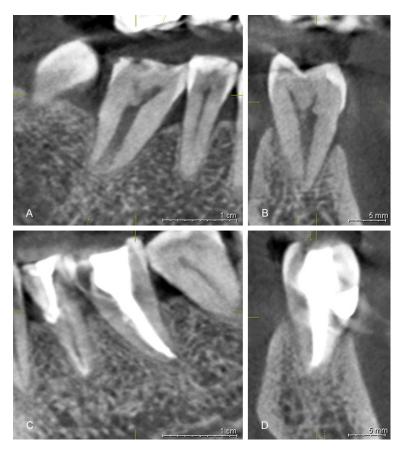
The cone-beam computed tomography image of the right mandibular first molar in the transverse (A) and sagittal section (B), as well as the left mandibular first molar in the transverse (C) and sagittal section (D).
